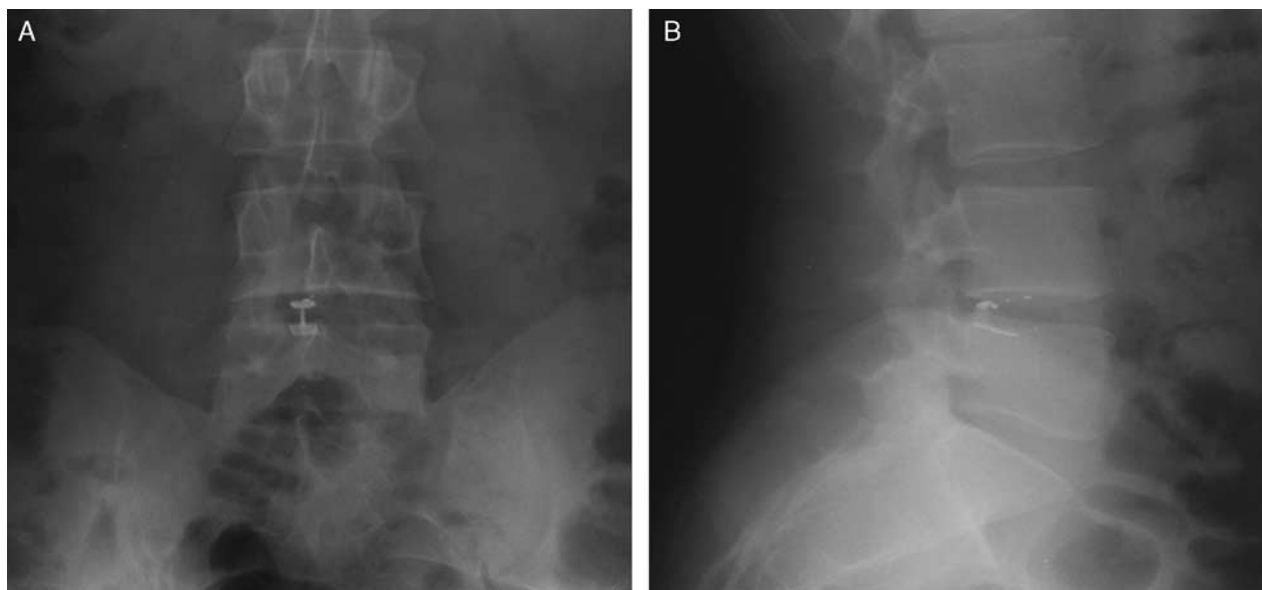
Anterior-posterior (A) and lateral (B) x-ray radiographs of the lumbar spine, demonstrating Barricaid implantation.
